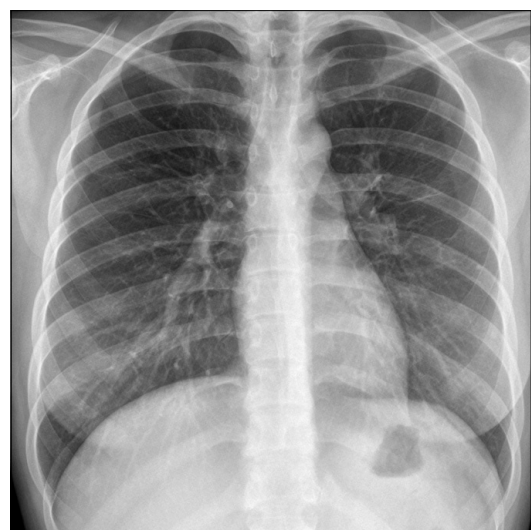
Chest radiography obtained 4 days after that presented in Fig. 1 shows complete resolution of pulmonary edema.
